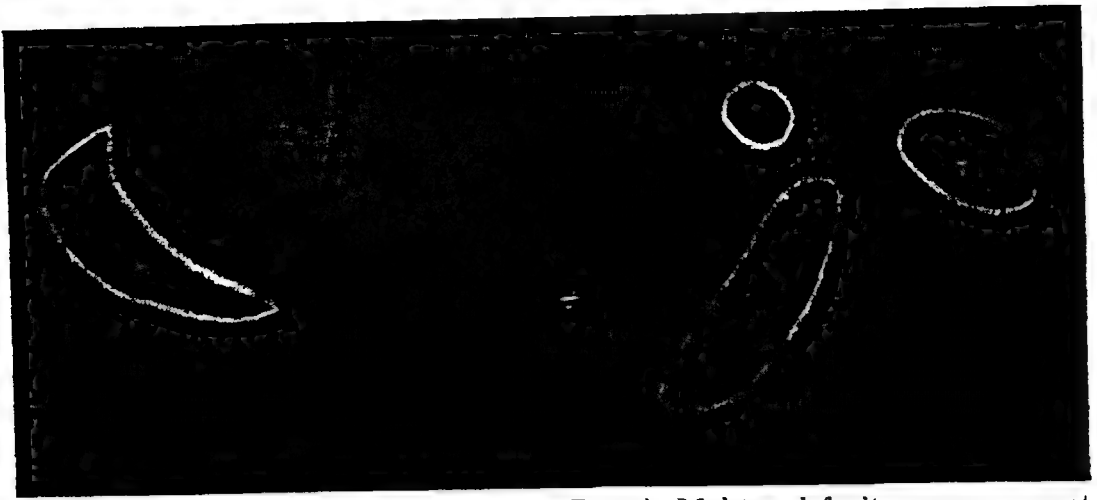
ORTHODYNAMIC RADIOGRAPH (X-RAY PAPER) Mid-tarsal fault. excess imprint to medial aspect of inter-phalangeal area of great toe, medial sesamoid; general imprint to metatarsophalangeal joints, and typical excess by lateral heel border.
